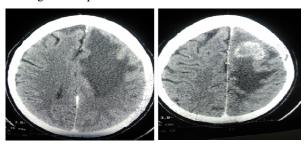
Initial CT scan at presentation, showing ring enhancing lesion at the frontotemporal area with significant perilesional edema
